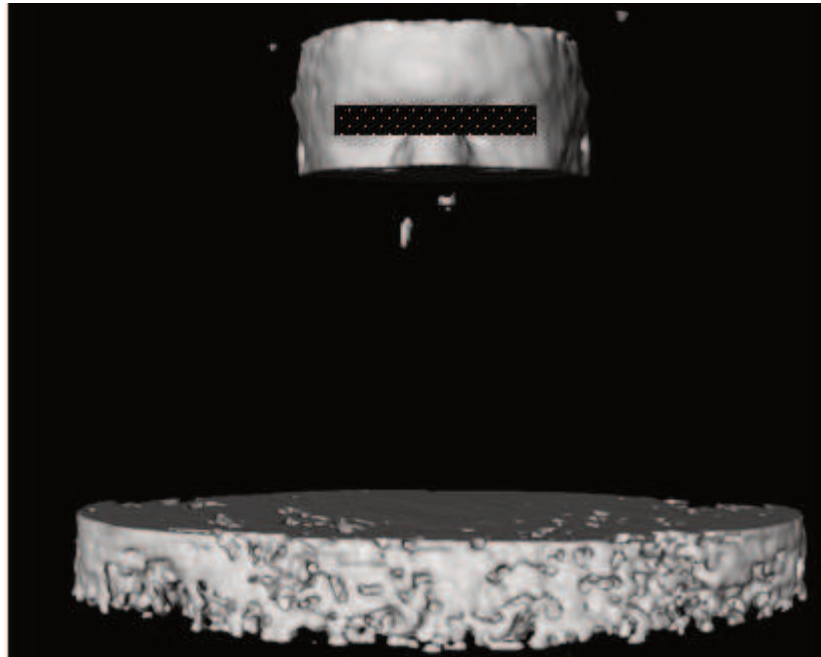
Renderer ISO surface of the segmented PET-CT
